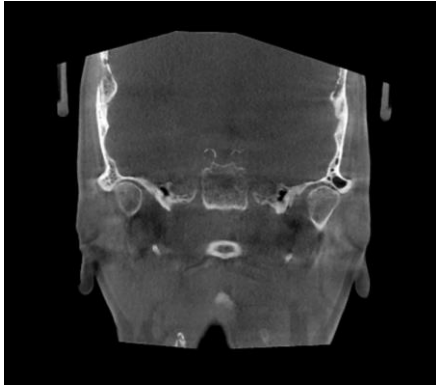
Patient G.F. 52 years - CBCT coronary sections of both TMJ - suspected bilateral compression in the joints. Normal bone structure.
